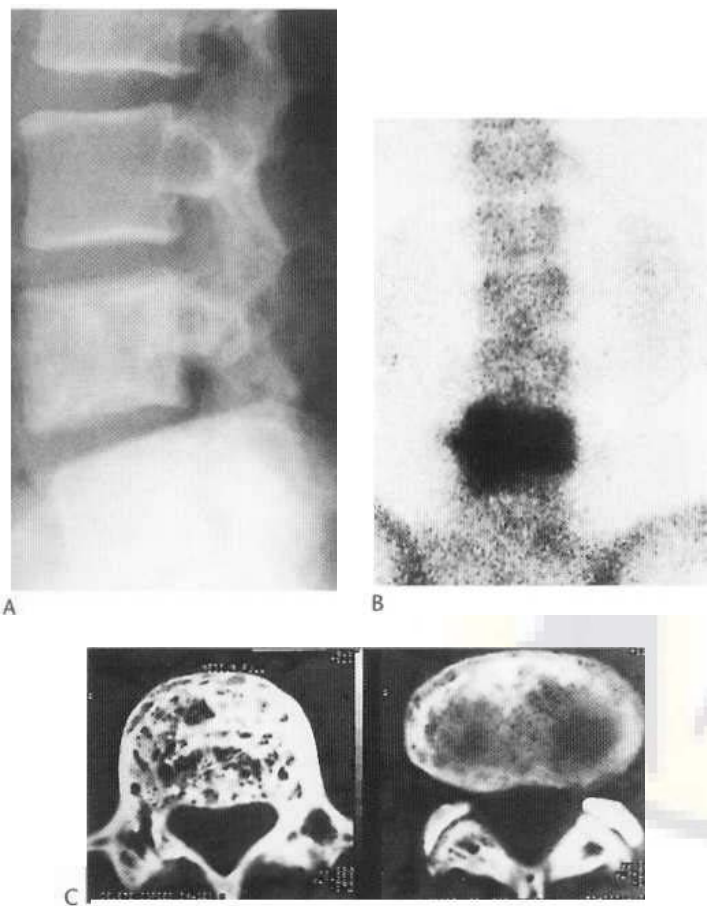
Paget's disease. (A) The affected vertebral body is expanded as well as showing abnormal texture. (B) The bone scan confirms the increase in uptake in the expanded vertebral body. (C) The CT scan shows the rather spongy texture of the abnormal body, extending into the pedicles and laminae.
